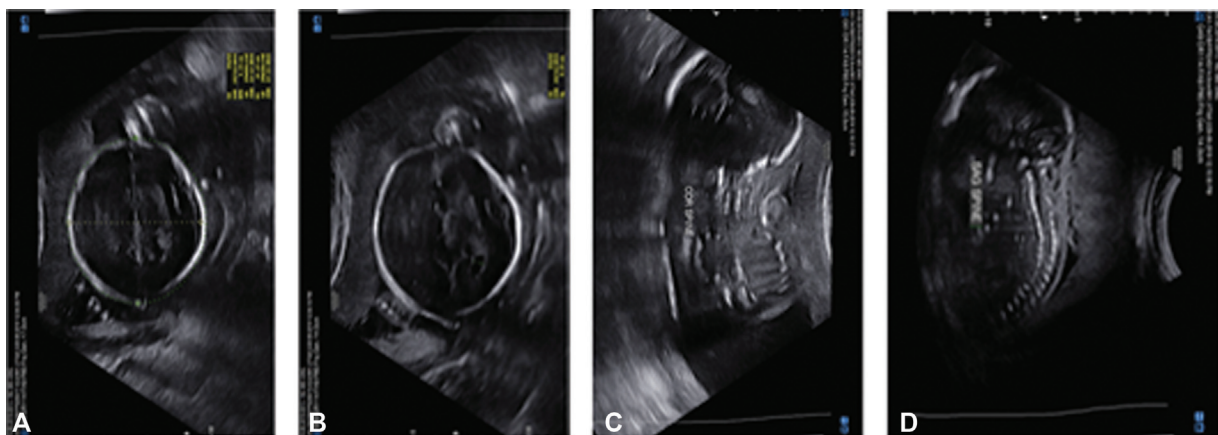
The fetal anomaly ultrasound scans performed at 24 weeks of gestation showed a normally developing brain (A and B—axial view, C—coronal view, and D—sagittal view).
